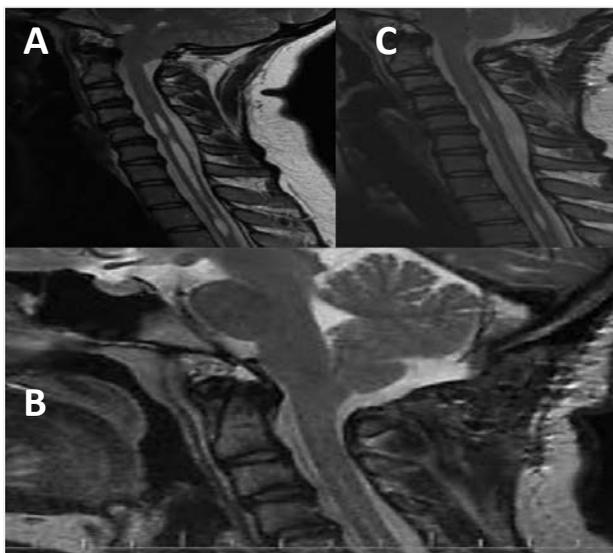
A: Preoperative sagittal MRI images of a 31-year-old female patient. B: Postoperative sagittal MRI. C: Postoperative MRI showing resolution of syringomyelia after 6 months.
